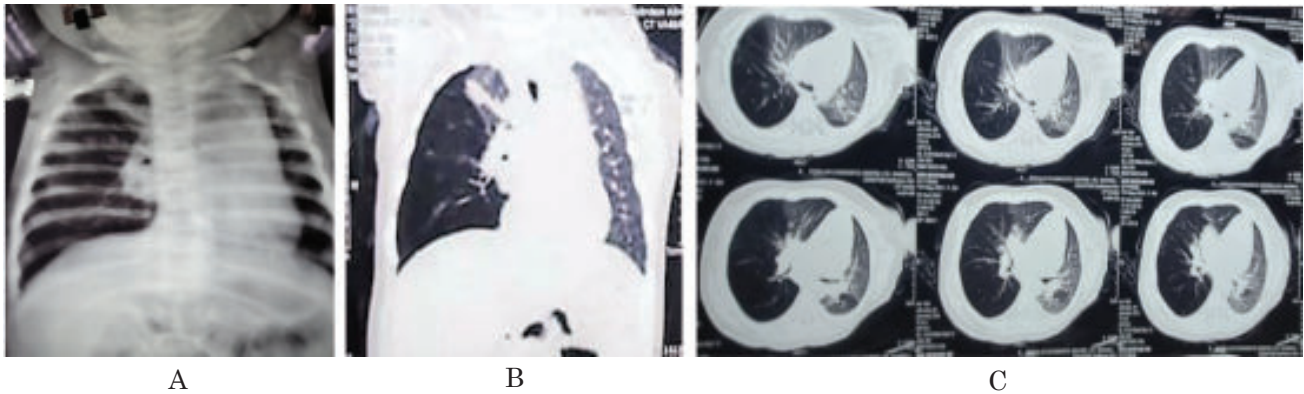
(A) Shows Chest x-ray, (B & C) Shows, CT Scan of chest.
